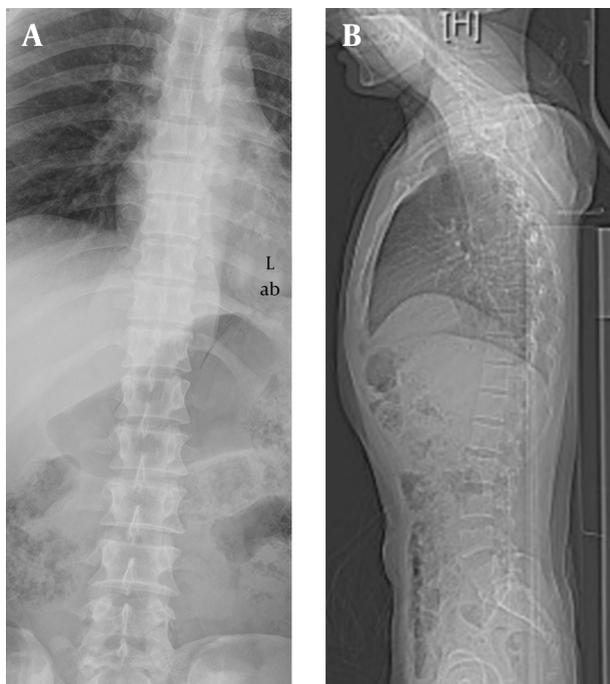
Radiographs of Spine (Anteroposterior and Lateral) Showing no Sign of Vertebral Column Disruption
